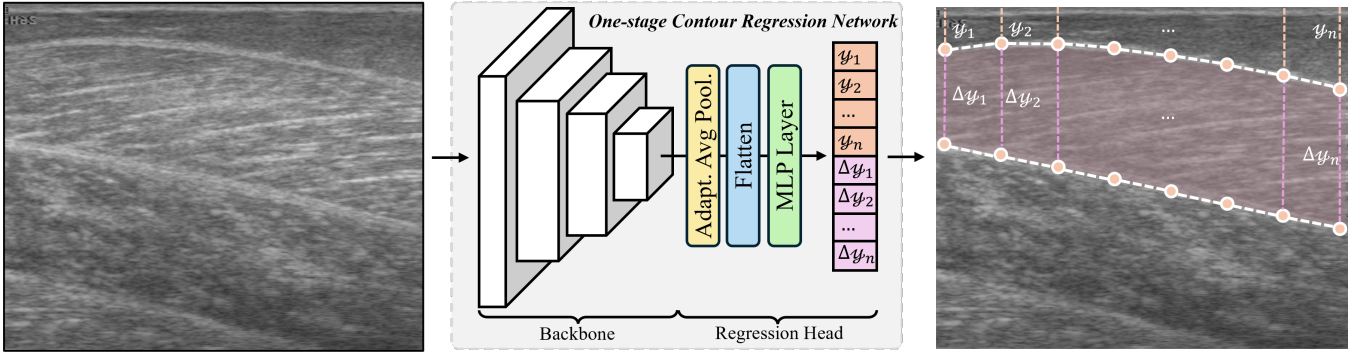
Overview of our methodology. The model takes an ultrasound image as input and outputs the coordinates of contour points on the superficial aponeurosis and the corresponding offsets for the deep aponeurosis.
